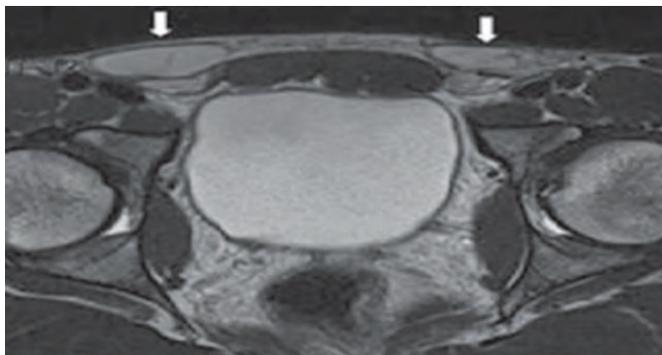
MRI Pelvis showing bilateral streak gonads
